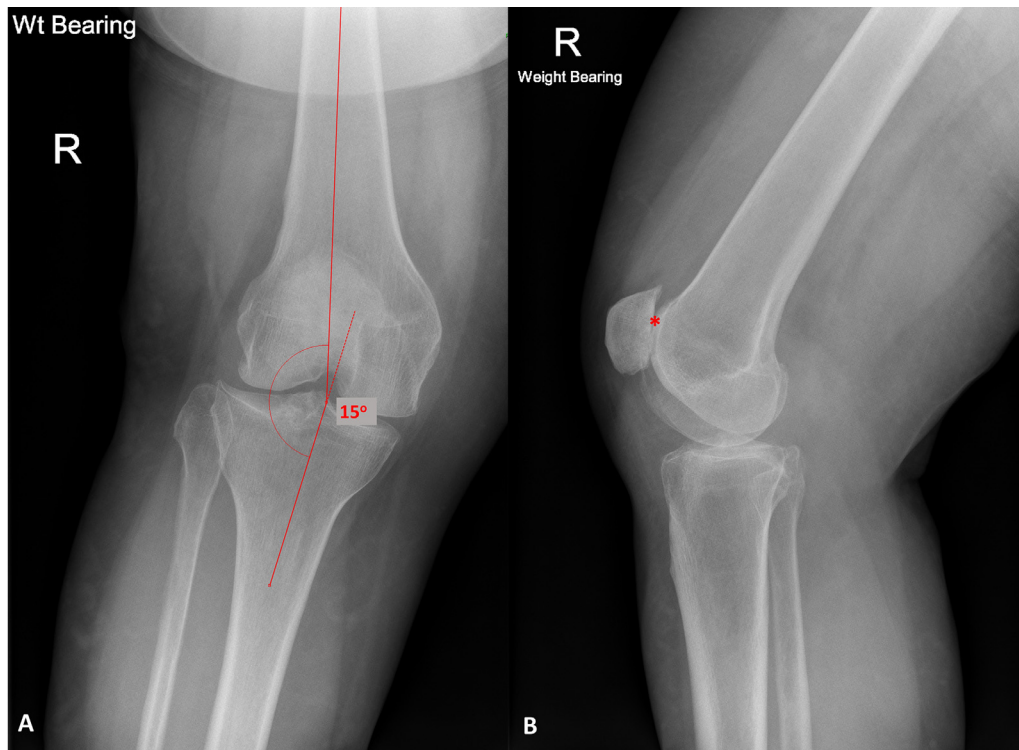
AP (A) and lateral (B) radiographs of the right knee. There is an anatomical tibiofemoral angle of 15 degrees in keeping with genu valgum (lines). There is severe patellofemoral osteoarthritis as evidenced by joint space loss and subchondral sclerosis (asterisk).
